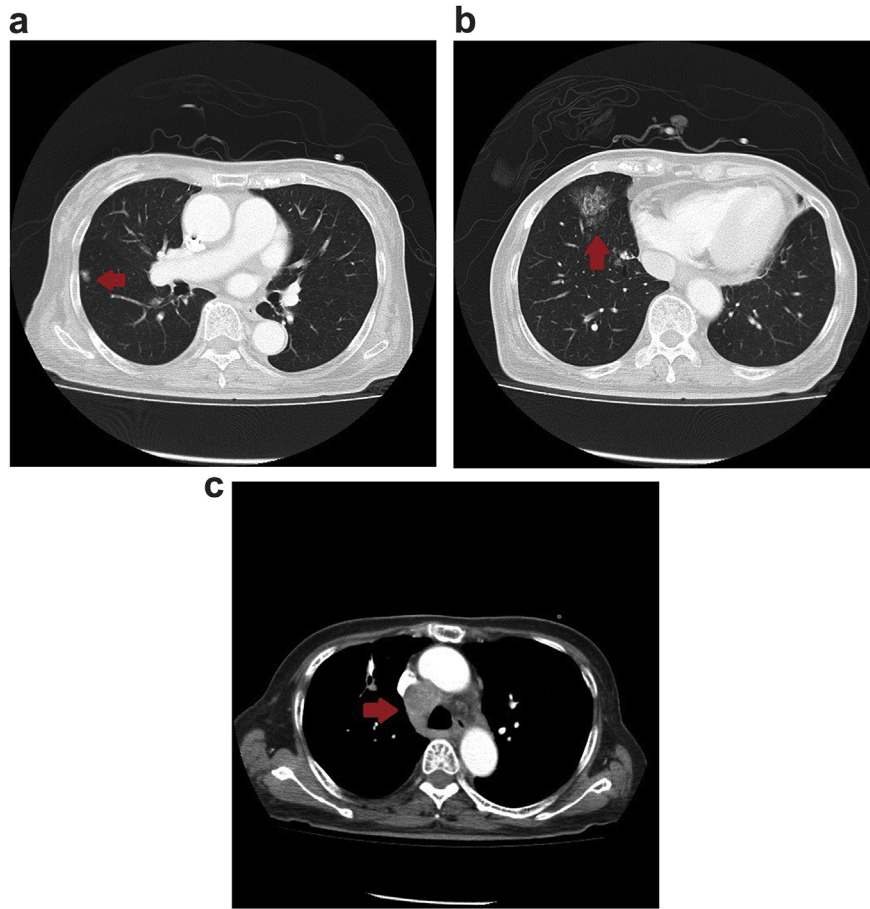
CT images of chest after recurrence (a, b and c).
